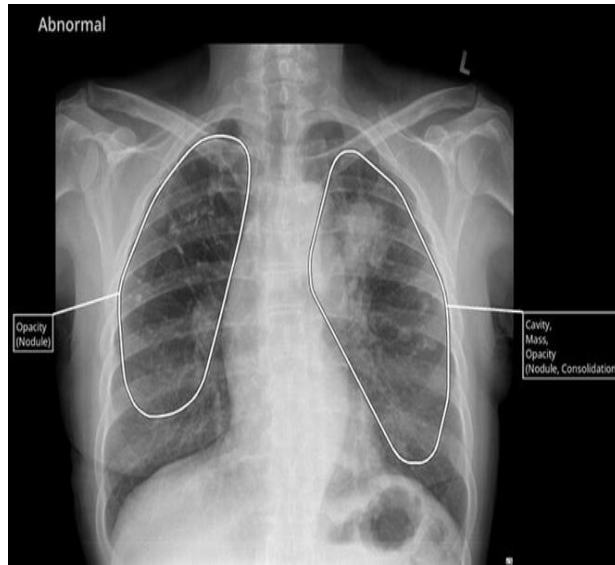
An example of a chest radiograph of a patient with lung cancer [112].
